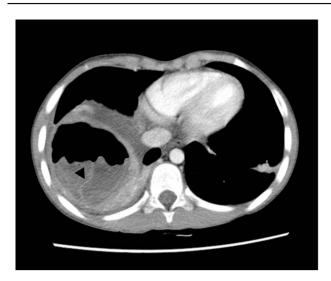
Axial CT scan of the chest of the same patient showing the cavitary lesion with its irregular wavy air—fluid level and internal septation representing a collapsed membrane (arrow head).
